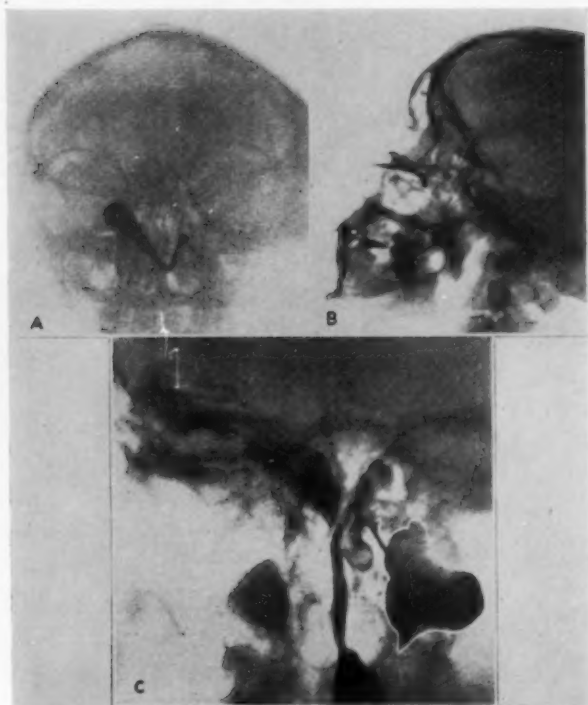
Roentgenographic studies showing (A and B) canula in oblique passageway; (C) passageway after instillation of iodized oil.
